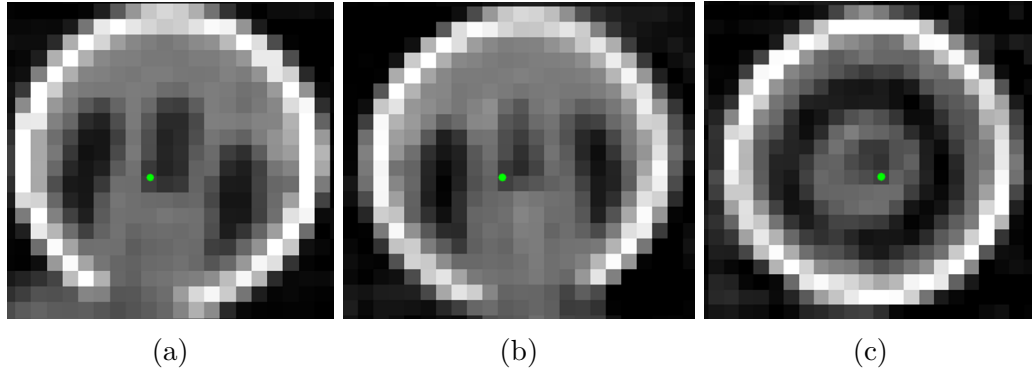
Sphere detection using the spherical Hough transform algorithm. The green dot represents the center of a retroreflective marker with a radius of 7.5 mm. a) Sagittal CBCT slice b) Coronal CBCT slice c) Axial CBCT slice.
